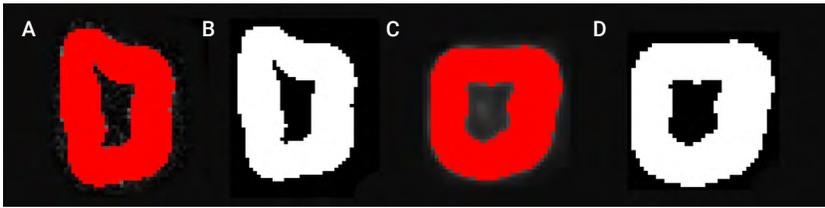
Image segmentation process before and after a binarization. Non-binarized micro-computed tomography image (A); binarized micro-computed tomography image (B); non-binarized Cone beam computed tomography image (C); binarized Cone beam computed tomography image (D).
